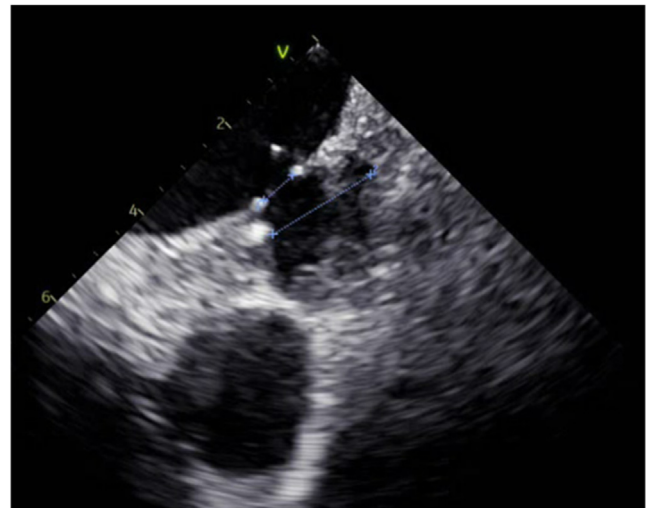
Four-dimensional intracardiac echocardiography catheter in left atrium used for final measurements of left atrial appendage occluder device.
